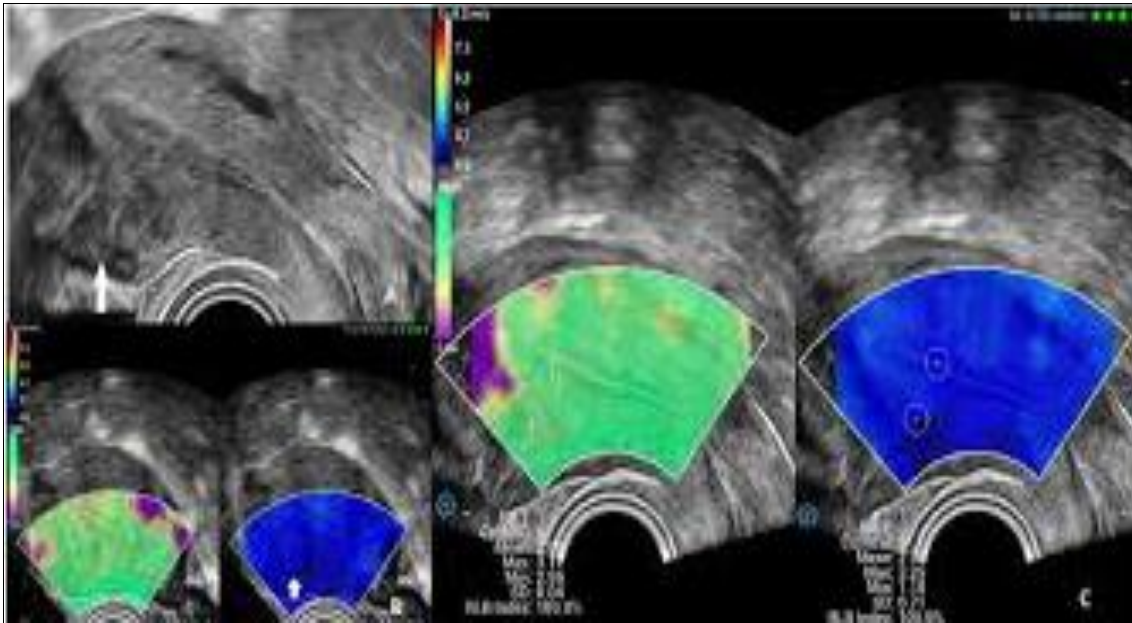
Uterine fibroids are diagnosed with SWE. A transvaginal ultrasound revealed a white arrow-marked hypoechoic lesion in the anterior inferior uterine region. B, SWE displayed a pseudo capsule with a lighter blue hue that circled the fibroid (shown by a white arrow). C, Finding the area of interest at lesion 2, and automatically measuring the shear wave speed (Cs).
